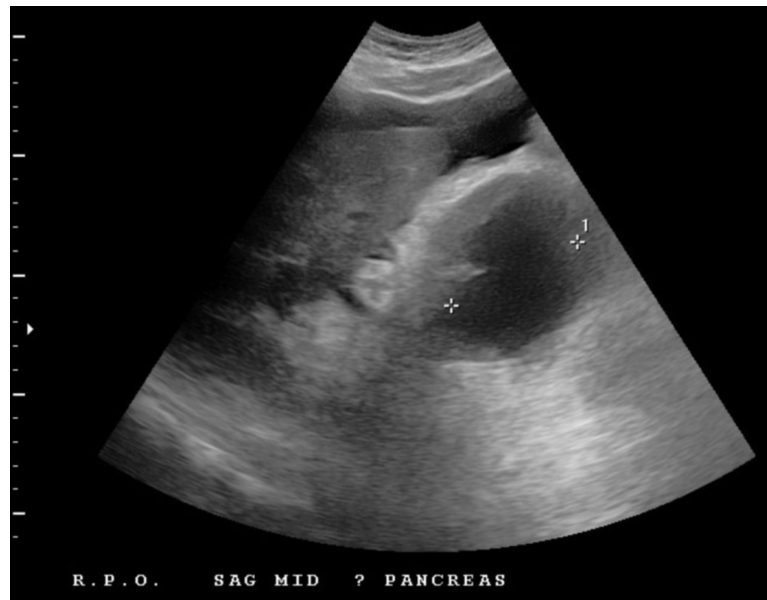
Ultrasound of the right upper quadrant/epigastric region demonstrates a hypochoic collection in the region of the head of the pancreas. The suggestion of a tissue wall separates this collection from the ascites fluid in the abdomen.
